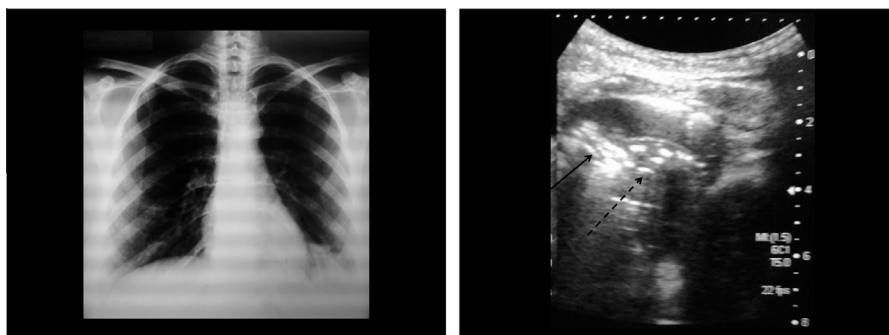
(a) Chest X-ray showed Lt basal paracardiac homogenous shadow associated with obliterated Lt costophrenic angle. (b) Longitudinal US image showed Lt basal lung consolidation containing both air bronchogram (solid arrow) and fluid bronchogram (dashed arrow) associated with minimal pleural effusion.
